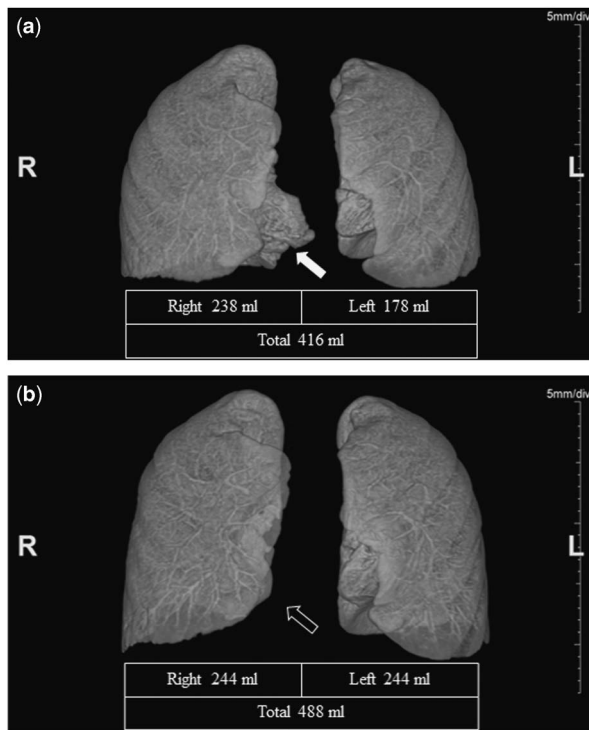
Lung volumetric analysis by computed tomography (a) before and (b) after lobectomy. Right lung volume increased from 238 to 244 ml after lobectomy, despite resection of the right lower lobe (open arrow). Left lung volume also increased from 178 to 244 ml. The white solid arrow indicates the sequestered lobe before lobectomy.
